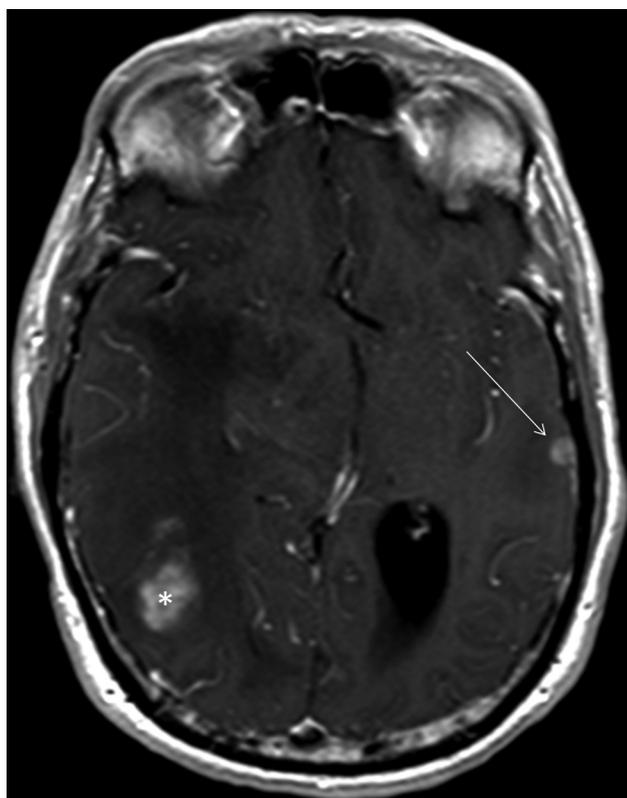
Postaxial T1 weighted MRI with contrast: right occipitotemporal, cortically based, heterogeneously enhancing lesion with surrounding vasogenic edema (*). Left temporal enhancing lesion (arrow) with surrounding edema. Midline shift with increased mass effect upon right lateral ventricle.
